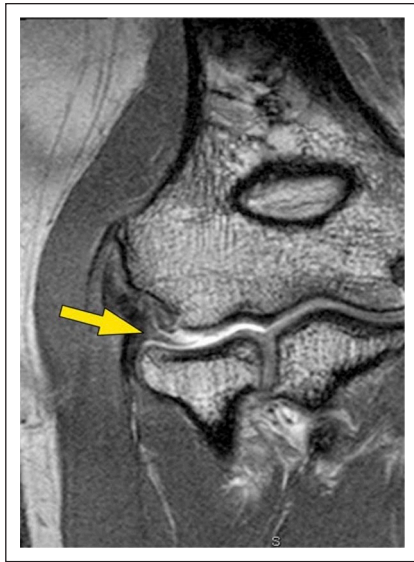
MRI of radiocapitellar plica (yellow arrow).
